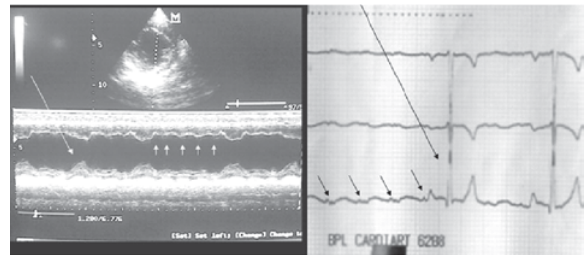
Right parasternal short axis echocardiographic view
